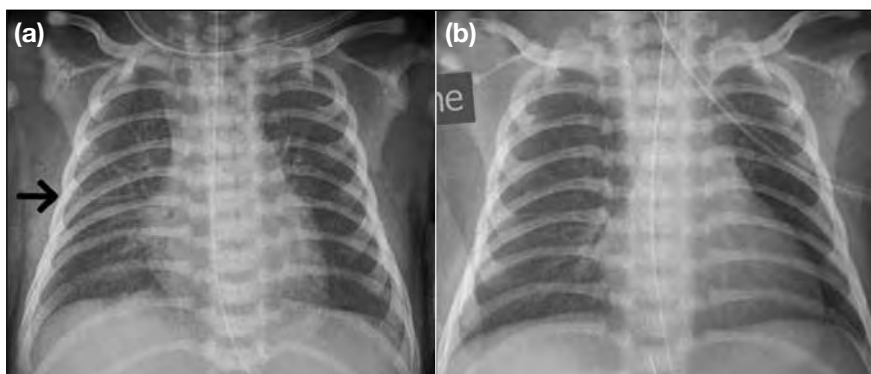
Typical radiographic appearance of transient tachypnoea of the newborn. A 39+4 weeks term baby girl delivered vaginally developed respiratory distress soon after birth. (a) Chest X-ray on day 0 showing hyperinflated lungs, increased perihilar streaky opacities and thickened right horizontal fissure (arrow). (b) Chest X-ray on day 1 after minimal ventilatory support showing clearance of perihilar opacities and improvement of pleural effusion.
